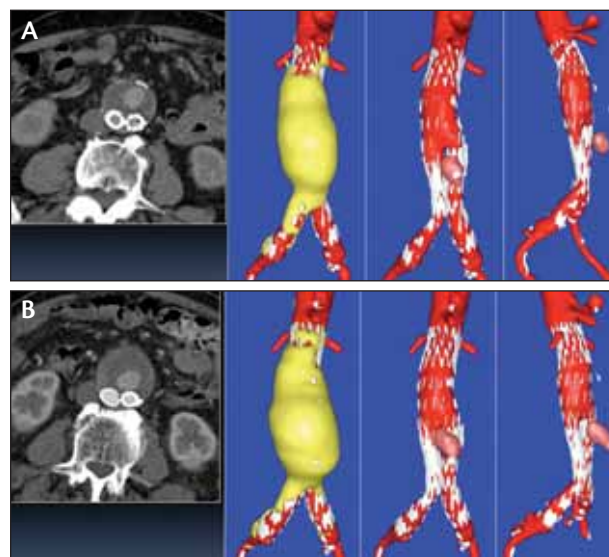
Type II endoleak on initial post-EVAR CT scan (A). CT scan follow-up at 3 years post-EVAR (B).
